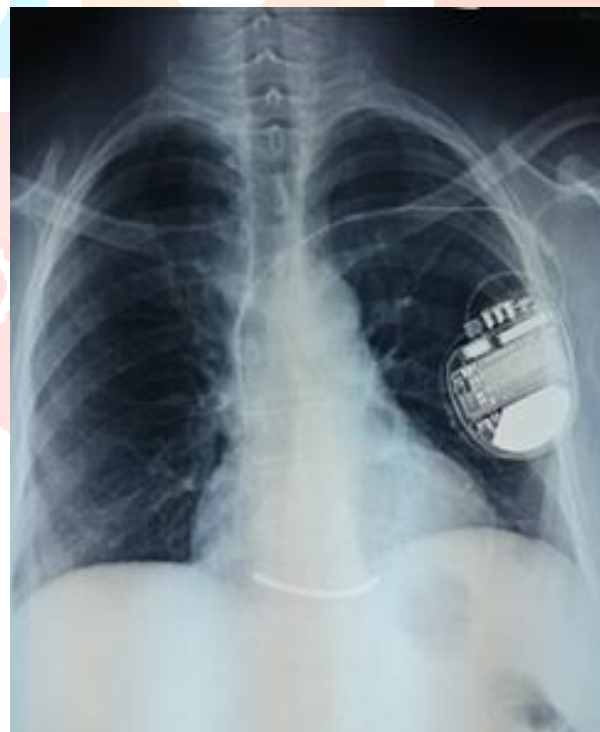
chest Xray after implantation of DAI
